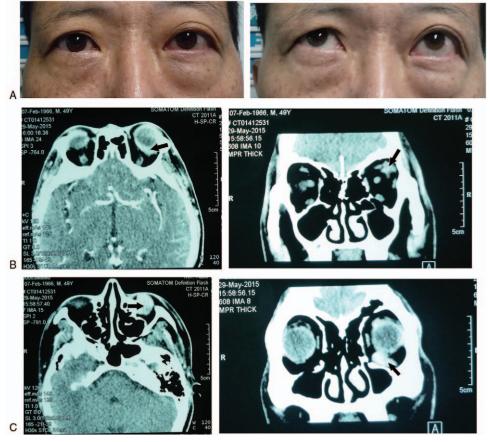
(A) The appearance of the eyes with left orbital tumors. (B and C) Computed tomography scans revealing the location of the orbital tumor (arrows) in the superior orbit (B) and the inferior orbit (C).
